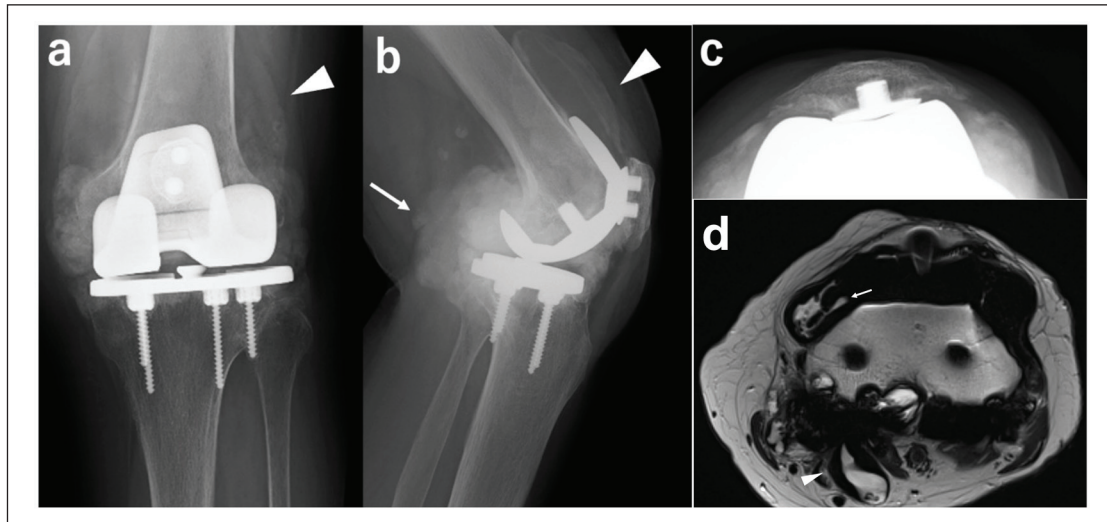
Radiographs and magnetic resonance image. In the preoperative radiographs, the cloud sign (arrow) and metal-line sign (arrowheads) are observed (a: anterior–posterior view, b: lateral view). The space between the patella and femoral components has disappeared (c: axial view). Magnetic resonance image demonstrates fluid retention (arrow) and synovial hyperplasia (arrowhead) within the joint and posteriorly outside the joint capsule (d: magnetic resonance imaging T2-weighted axial image).
